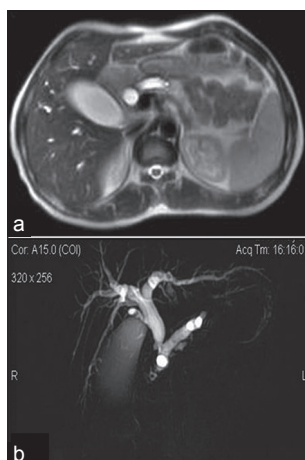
T2-weighted image showing double duct sign due to periampullary carcinoma (dilated common bile duct and pancreatic duct) (a) and magnetic resonance cholangiopancreatography image confirming it (b)
